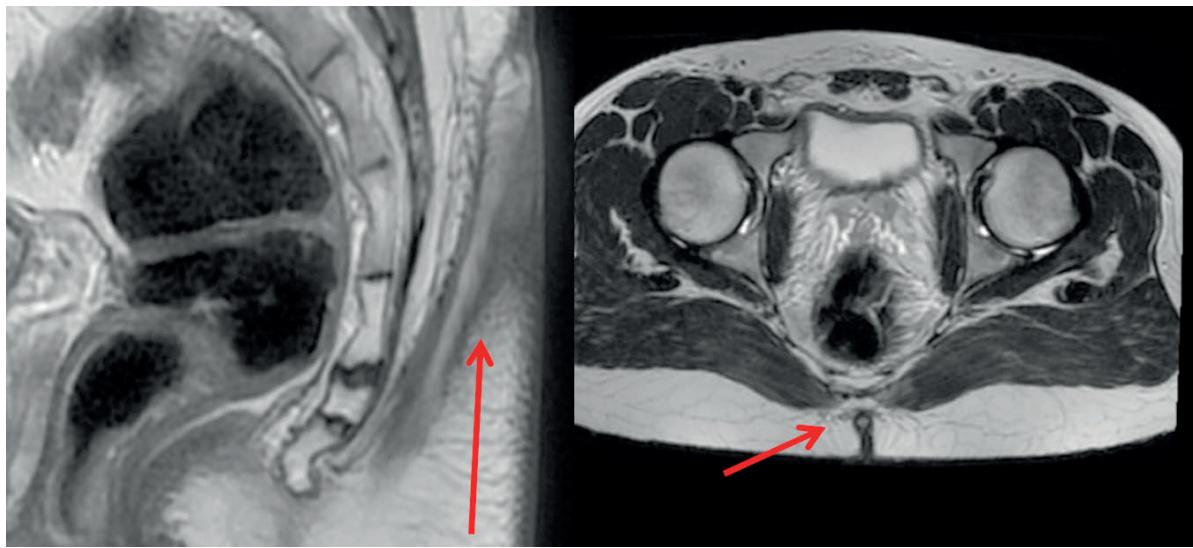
Magnetic resonance imaging of the pelvic organs with intravenous contrast: A — sagittal view T2-weighted image (the arrow indicates the cavity. A layer of subcutaneous fatty tissue was preserved between the cavity and sacral fascia); B — axial view T2-weighted image (arrow indicates cavity)
